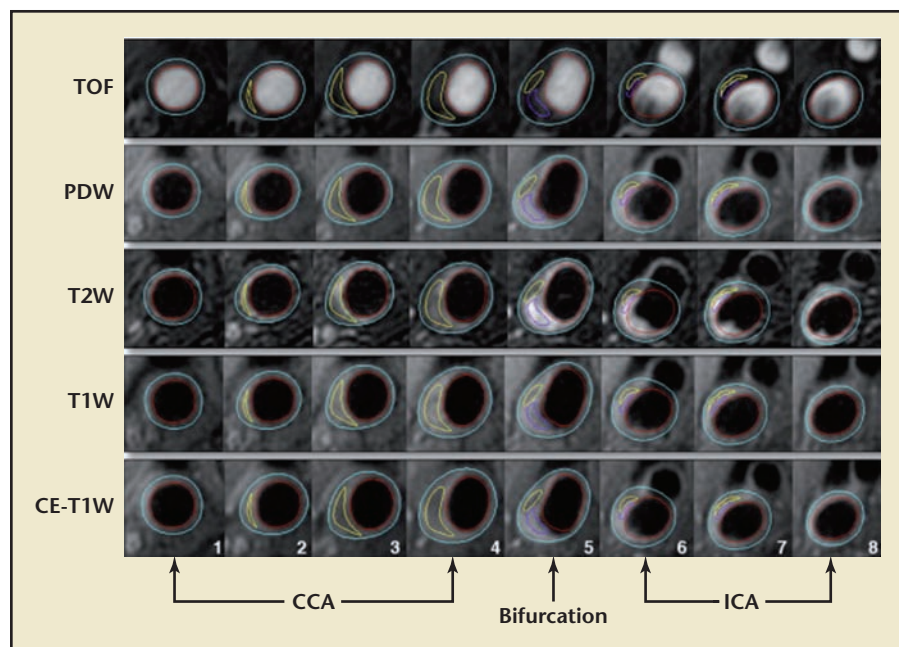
Example of carotid artery in multicontrast MRI. MRI example of eight consecutive images of the CCA through bifurcation to the ICA from five contrast weightings: TOF, PDW, T2W, T1W, and postcontrast T1W. The lumen in red and outer wall boundary in blue of the carotid artery are identified and outlined. Plaque tissue components within the arterial wall are identified using an established algorithm and quantified (loose matrix in purple and lipid content in yellow). For example, lipid content in yellow appears isointense on the TOF and pre-contrast T1W images and hypointense on PDW and T2W images, and has no contrast enhancement compared with the surrounding tissue on post-contrast T1W images. Total LRNC volume is calculated by multiplying the slice thickness (2 mm) by the sum of the areas circled in yellow color on the eight consecutive images. Percent LRNC (%LRNC) is the proportion of the wall occupied by the LRNC only in the lipid-containing slices, from slice #2 to #7. CCA, common carotid artery; ICA, internal carotid arteries; LRNC, lipid-rich necrotic core; MRI, magnetic resonance imaging; PDW, proton density-weighted; T1W, T1-weighted; T2W, T2-weighted; TOF, time of flight. Reprinted from Serruys PW et al. J Am Coll Cardiol. 2011;58:1578-1588; with permission from Cardiosource.
